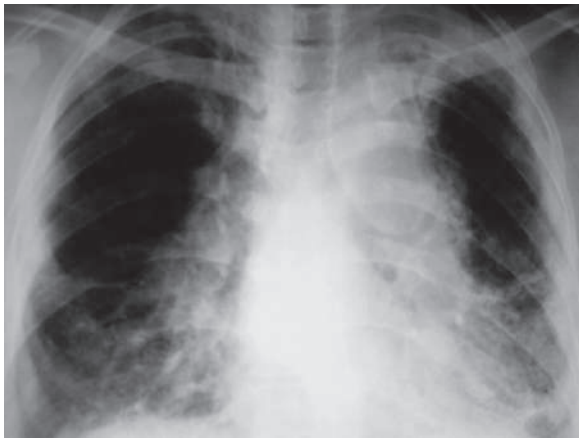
Posteroanterior chest radiograph of a patient with chronic grade 4 pulmonary sarcoidosis shows bilateral lung fibrosis distorting the heart silhouette (shaggy heart appearance)
